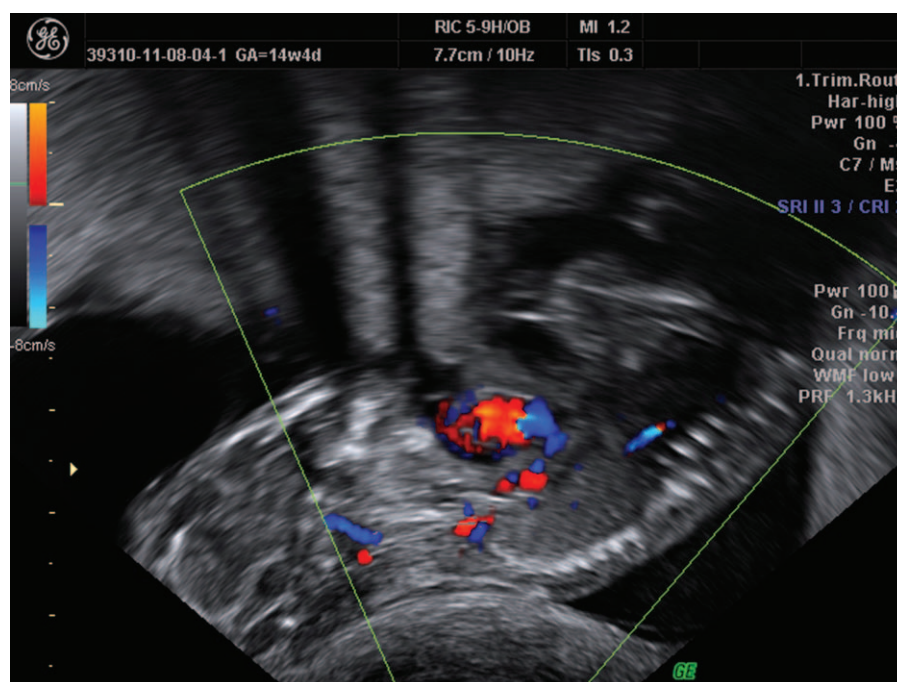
Pregnancy 14 weeks of amenorrhea. Color Doppler ultrasound is helpful for the diagnosis of ectopia cordis. The arrow indicates the ectopic heart and the head.
